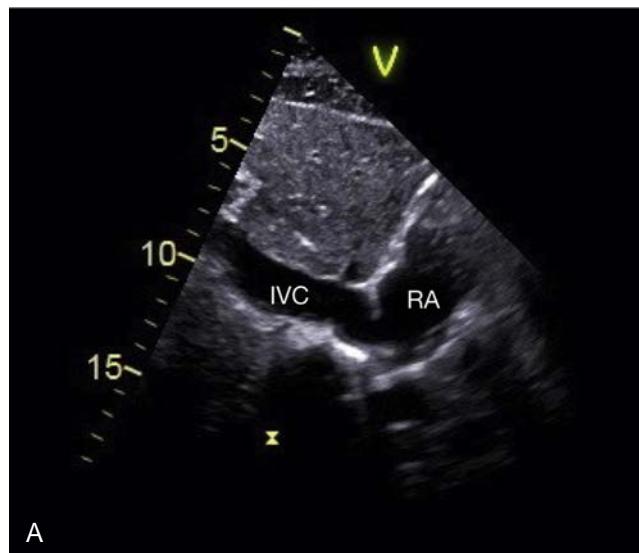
Transthoracic subcostal views included in focused cardiac ultrasound. (A) The subcostal inferior vena cava (IVC) view is shown. The IVC diameter and collapsibility index are measured in this view to estimate right atrial pressure in spontaneously breathing individuals (see text). (B) The subcostal four-chamber view is shown. This view is useful for ultrasonographic examination during cardiac arrest, because it can be performed without interrupting chest compressions. *LA*, Left atrium; *LV*, left ventricle; *RA*, right atrium; *RV*, right ventricle.
